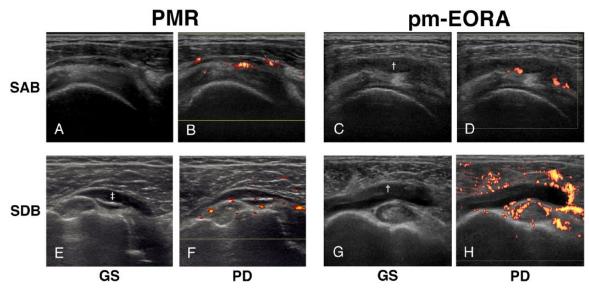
(A-D) Representative US images of the bursitis of SAB and (E-H) SDB. Images from the shoulders of patients with (A, B, E, and F) PMR and (C, D, G, and H) pm-EORA are shown in (A, C, E, and G) gray-scale and (B, D, F, and H) power Doppler ultrasonograms. GS indicates gray scale; PD, power Doppler; pm-EORA, elderly onset rheumatoid arthritis with PMR-like onset; PMR, polymyalgia rheumatica; SAB, subacromial bursa; SCB, subcoracoid bursa; SDB, subdeltoid bursa; US, ultrasound.
